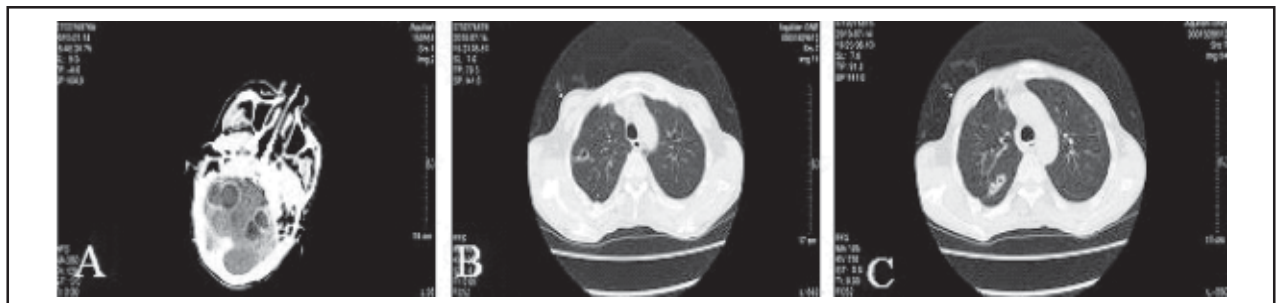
CT scan of the brain (A) and the chest (B, C).
